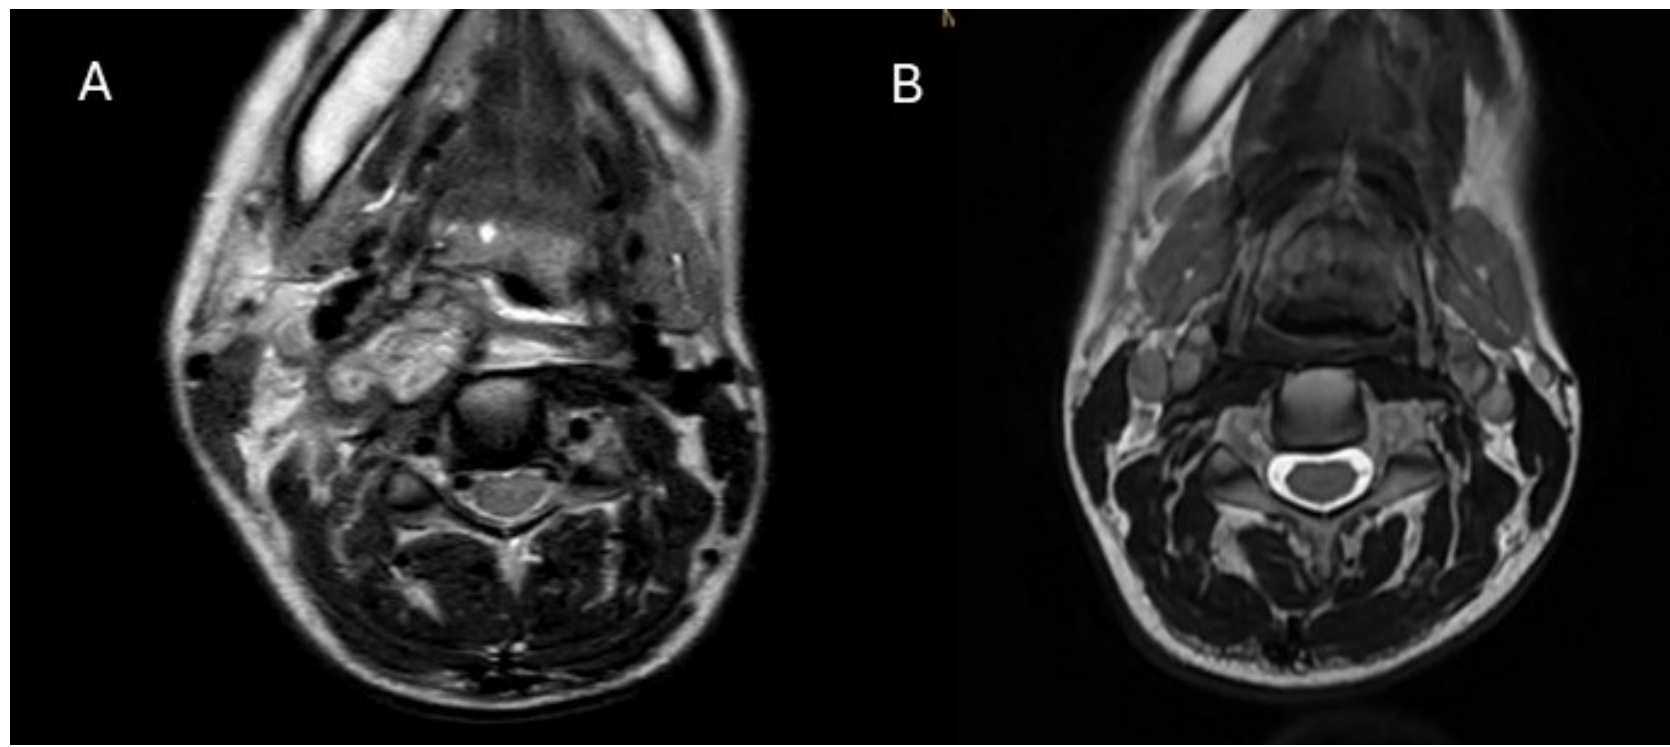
The axial T2-weighted MRI of case 4 shows the presence of irregular infiltration mass over the right side with extension to retropharyngeal space and carotid space before treatment started (A). The mass resolved after starting appropriate treatment (B).
